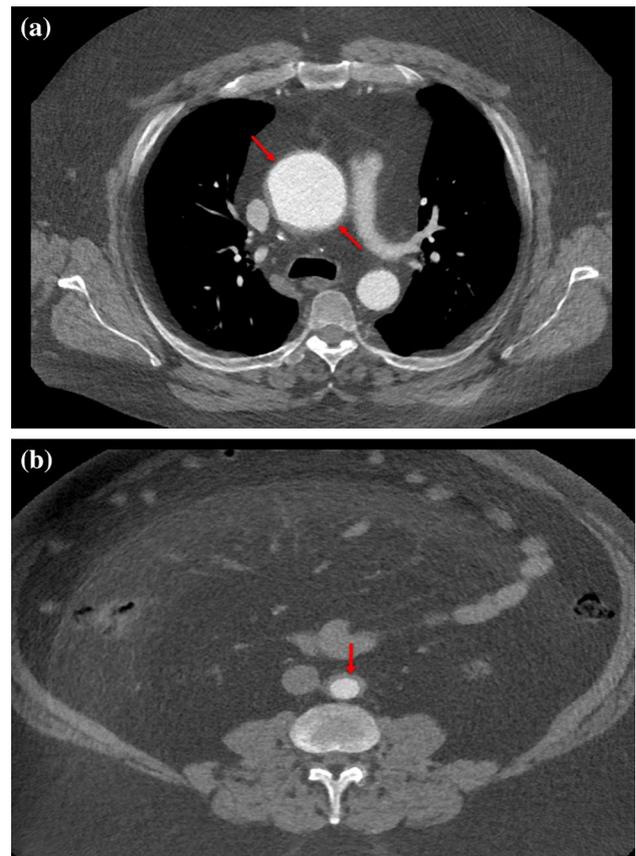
Transverse images of a CT angiogram of chest and abdomen revealing improved wall thickening of the a ascending aorta (2 mm) and b abdominal aorta (3 mm)
